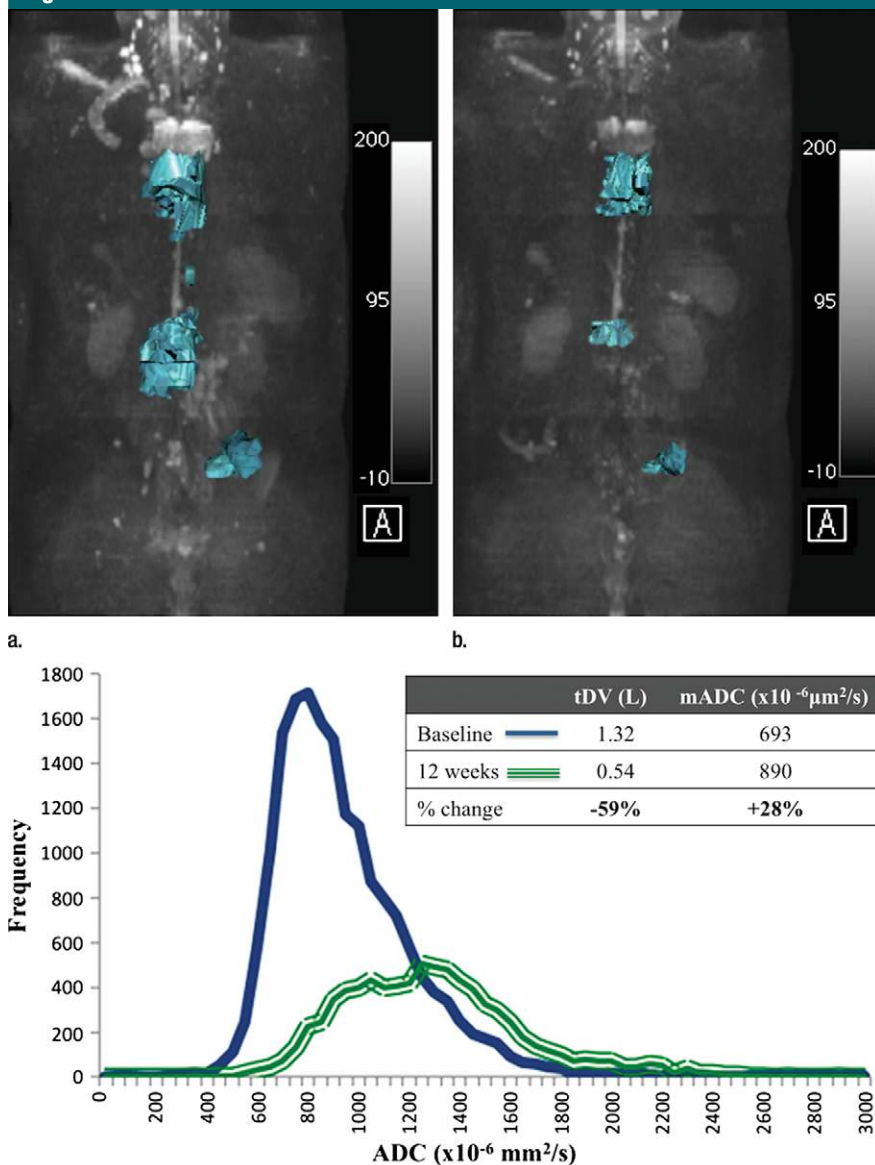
(a) Coronal baseline MR image and (b) coronal MR image obtained after 12 weeks of treatment in a 70-year-old man with mCRPC responding to olaparib show a reduction in the abnormal DWI signal intensity ($b = 900 \text{ sec/mm}^2$) extent on maximum intensity projection images. (c) Histogram depicts the ADC values of the tDV at baseline and after 12 weeks of treatment, showing an increase in the median ADC.
